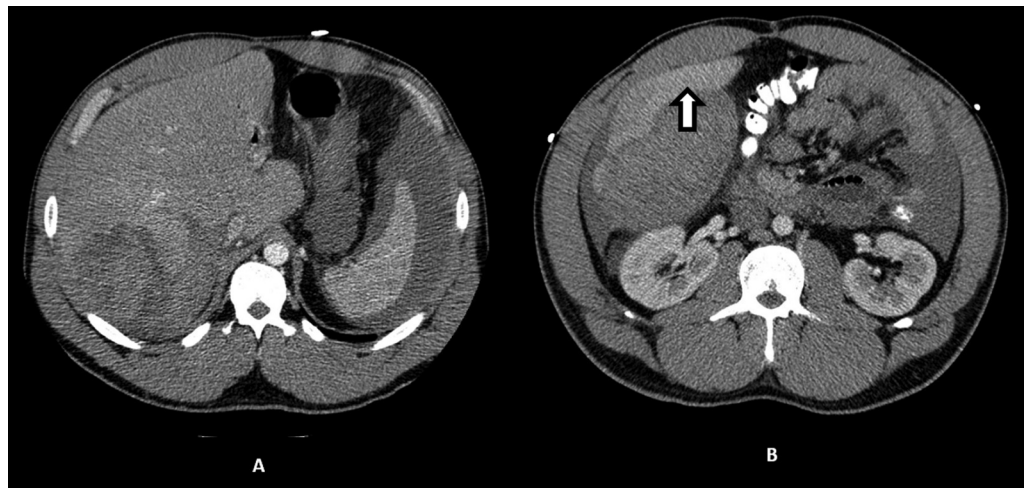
Contrast-enhanced computed tomography (CT) scans done on day 1 (A) and day 3 (B) of current presentation showed an interval increase in the hepatic hemorrhage with new subphrenic and anterior perihepatic/subcapsular components (indicated by the white block arrow).
